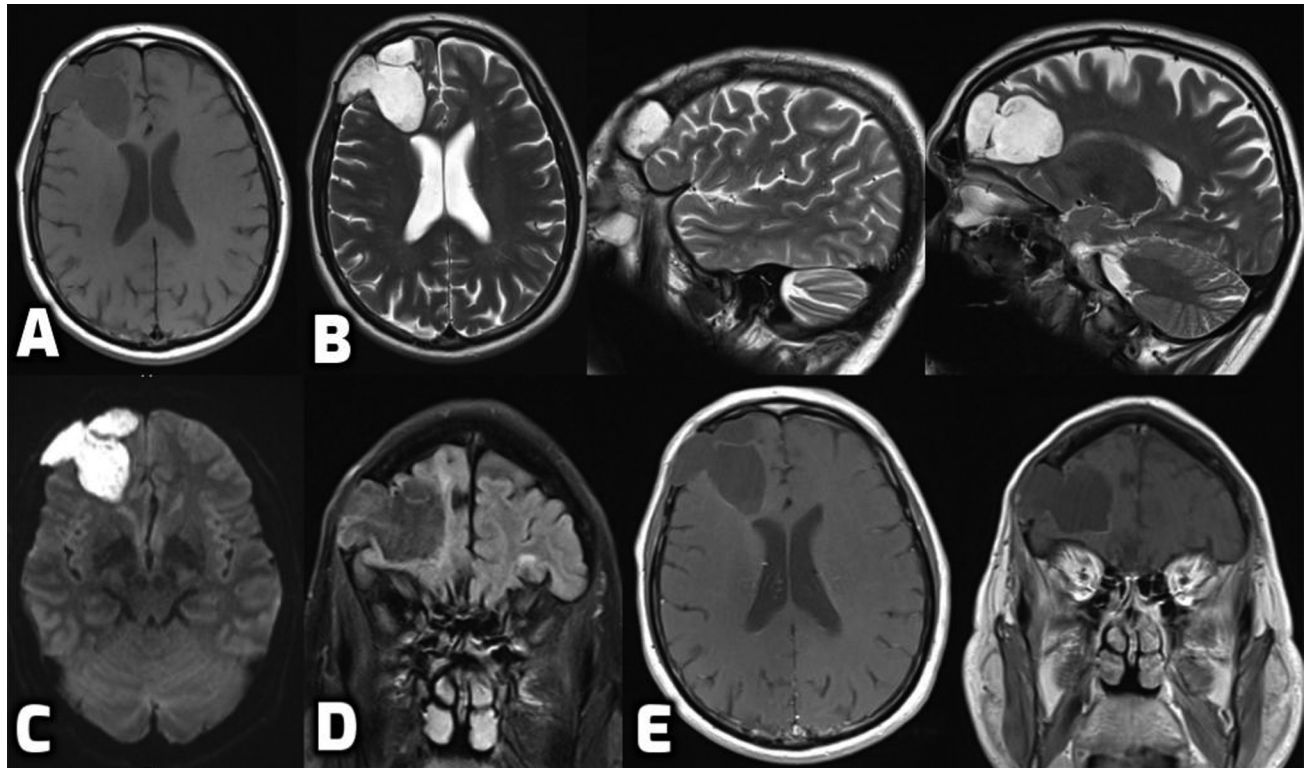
(A) T1-weighted axial magnetic resonance imaging (MRI) of the brain, (B) T2-weighted axial and sagittal, (C) diffusion-weighted image, (D) fluid-attenuated inversion recovery (FLAIR) coronal image, and (E) postcontrast axial and coronal images, from last follow-up showing no change in the characteristics of the lesion.
